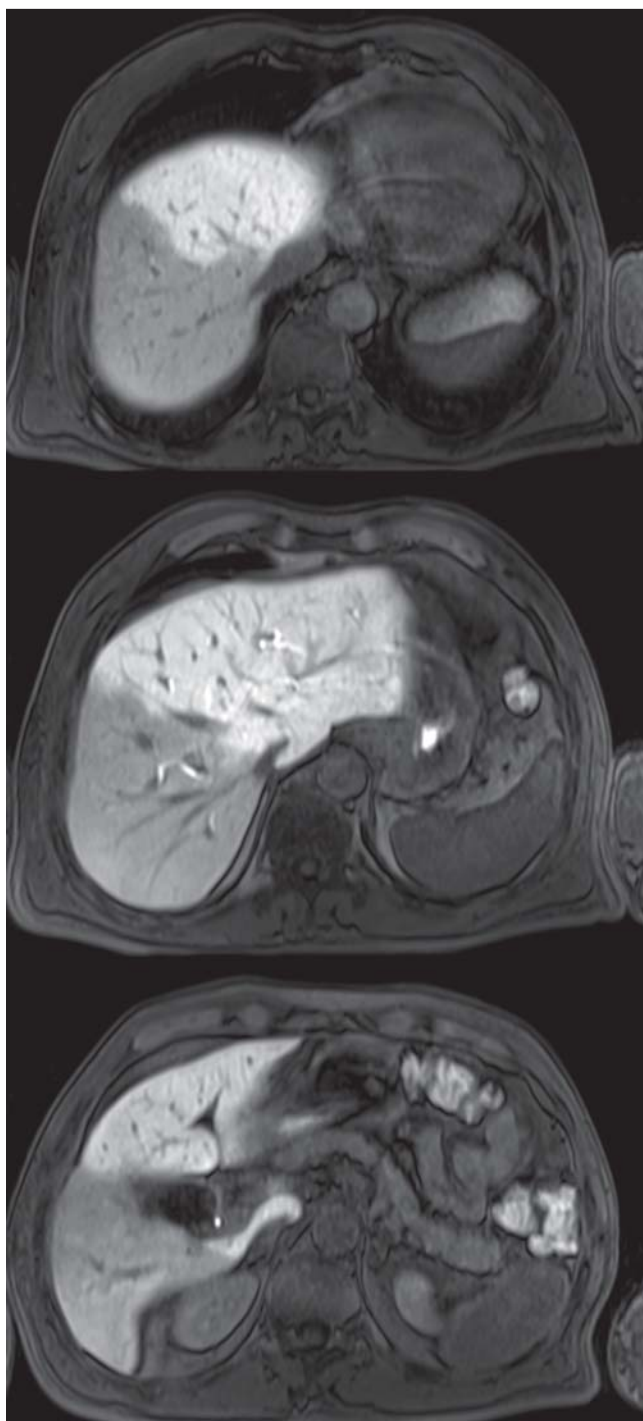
Gd-EOB-enhanced MRI 4 weeks after right portal vein embolization, T1-VIBE sequence after 20 minutes with flip angle of 30°. MRI with an increased excitation angle clearly shows the different signal intensities of the embolized and the non-embolized liver segments corresponding to a different function ratio.
